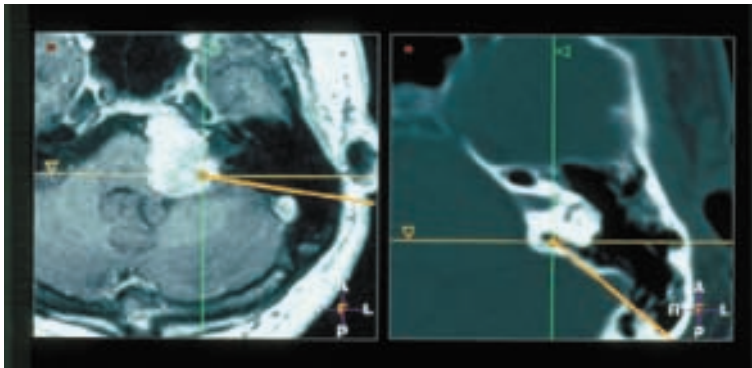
Intraoperative navigation in complex skull base surgery: image guidance during the transpetrous excision of a deep tumour in the cerebellopontine angle using dual registration with computed tomography (CT) and magnetic resonance (MR) scans. The CT (right) allows clear visualization of the inner ear and facial nerve during bone drilling and the surgeon may then switch to navigation with MR images when the tumour is reached (left).
